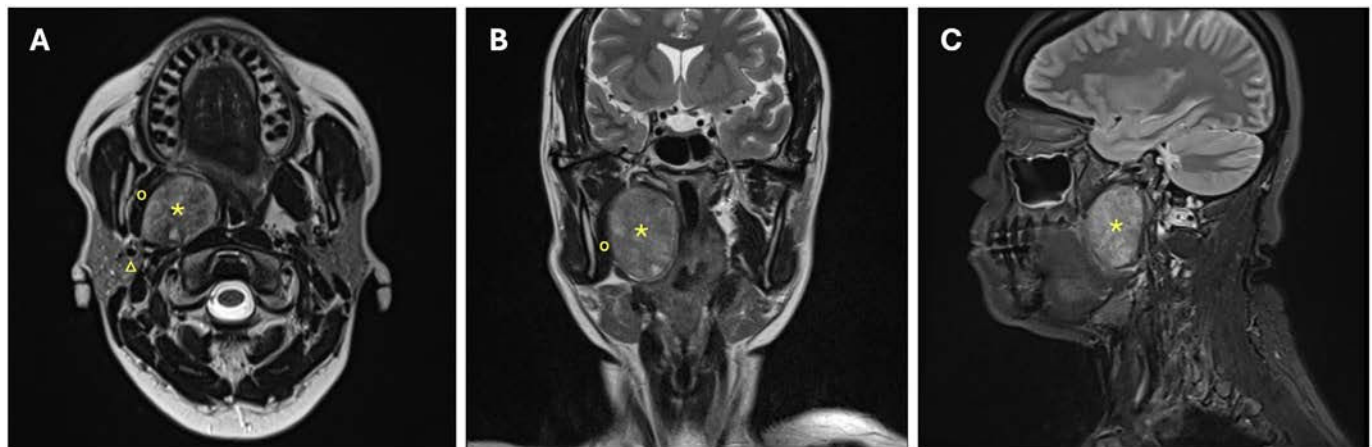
Maxillofacial magnetic resonance imaging (MRI), T2-weighted sequence, axial (A), coronal (B), and sagittal (C) sections, revealing a 5-cm solid, extramuscular tumor (*) located in the right prestyloid parapharyngeal space, exerting mass effect on the medial pterygoid muscle (") and displacing the oropharynx and base of the tongue. The tumor was in close contact with the deep lobe of the parotid gland (Δ) and did not present vascular invasion.
